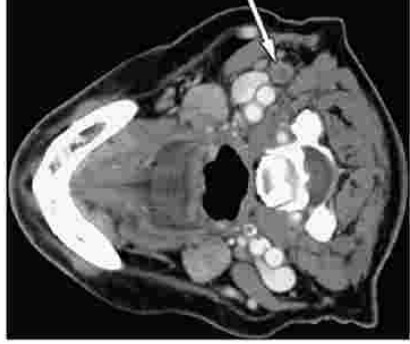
Focal low density within a normal sized lymph node (arrow) on postcontrast CT scan indicates metastatic disease.
